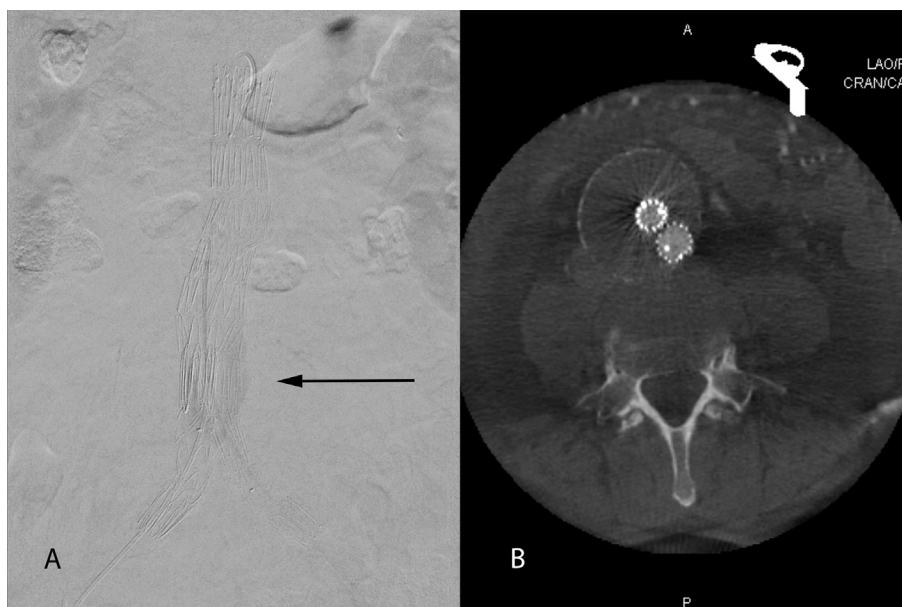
(A) Type 2 endoleak on the completion angiogram (arrow). (B) Contrast enhanced cone beam computed tomography did not show the type 2 endoleak.
